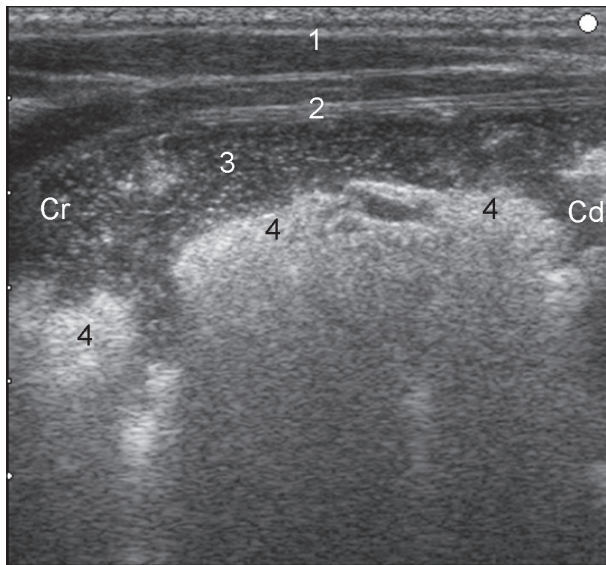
Ultrasonogram of the abomasum of a calf 30 minutes after feeding, viewed from ventral using a 5.0 MHz linear transducer. The abomasal contents are heterogeneous, and the clotted milk is seen as echogenic clumps. Hypoechoic fluid is visible at the periphery of the contents. 1 Ventral abdominal wall, 2 Abomasal wall, 3 Rim of hypoechoic fluid, 4 Clotted milk, Cr Cranial, Cd Caudal.
